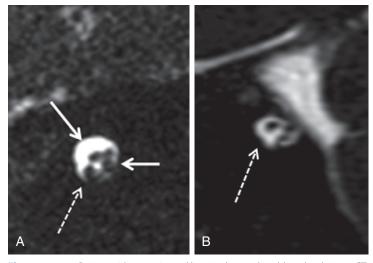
Patient with sensorineural hearing loss and cochlear dysplasia on CT: Cochlear nerve aplasia. A, Oblique sagittal FIESTA (fast imaging employing steadystate acquisition) sequence through the internal auditory canals on the normal side. *Solid upper arrow* points to the facial nerve. *Solid horizontal arrow* points to the superior and inferior vestibular nerves. *Dashed arrow* points to the cochlear nerve. B, Side with cochlear dysplasia: *dashed arrow* points to the expected location of the cochlear nerve, which is not present.
